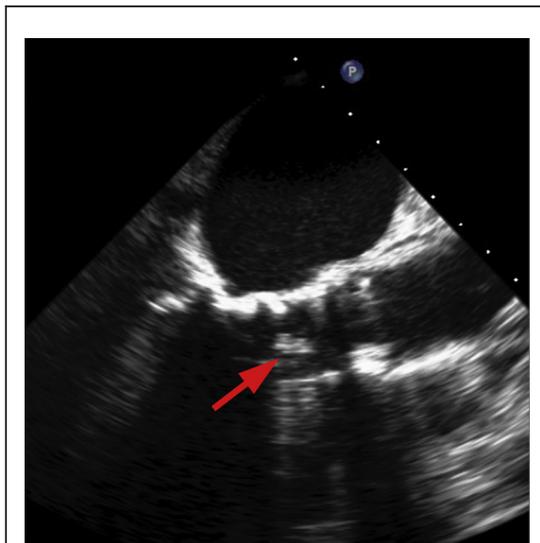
Transesophageal Echocardiogram After Prosthesis Deployment
